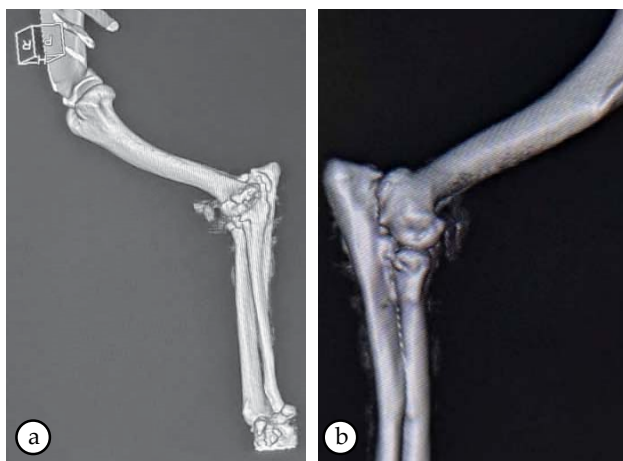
D reconstructed CT images of osteoarthritic elbow joint; showing osteophytes at elbow joint along with periostitis of radius and ulna.
